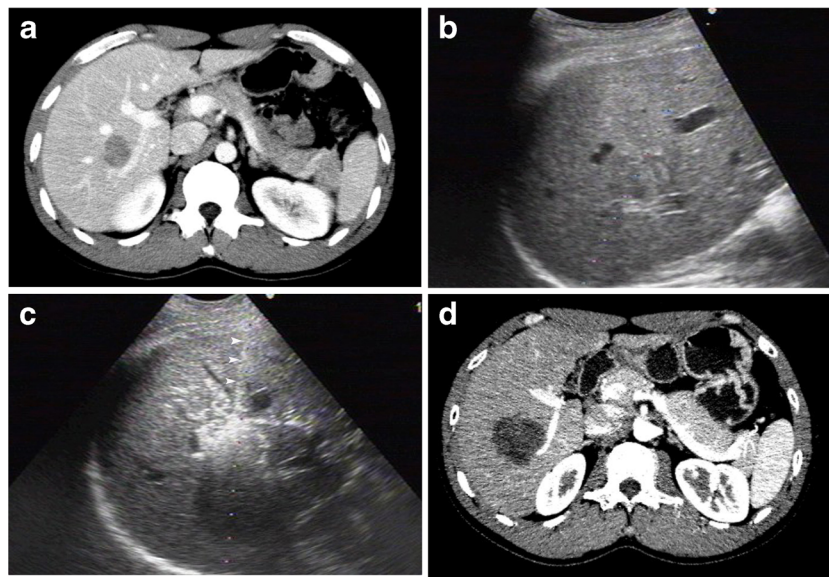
Images of a 36-year-old male patient with HCC who underwent multipronged ethanol injection and radiofrequency ablation using a multitined expandable electrode (Starburst XL electrode, RITA Medical Systems, Mountain View, CA). Pre-treatment CT (a) and ultrasound (b) show a 3.3×2.5 cm HCC adjacent to portal vein. c Tumour appeared
